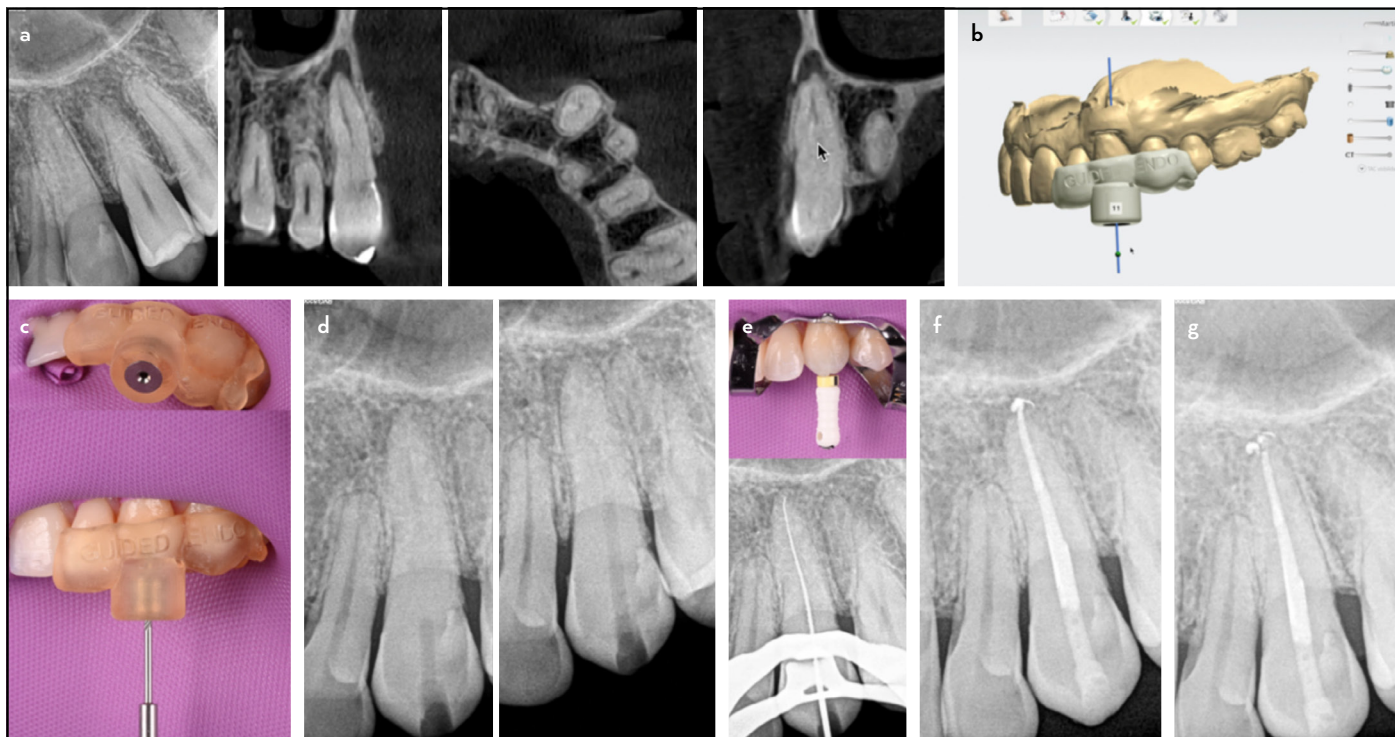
Case 1. (a) Preoperative radiograph and CBCT scan showing the degree of calcification in the root canal and periapical lesion. (b) Endodontic guide design. (c) Isolation, fit of the template, and guided access. (d) Intraoperative radiographs monitoring the trajectory of the bur. (e) Access to the working length with a K-file #15 file. (f) Postoperative radiograph. (g) Follow-up radiograph at one year and six months
